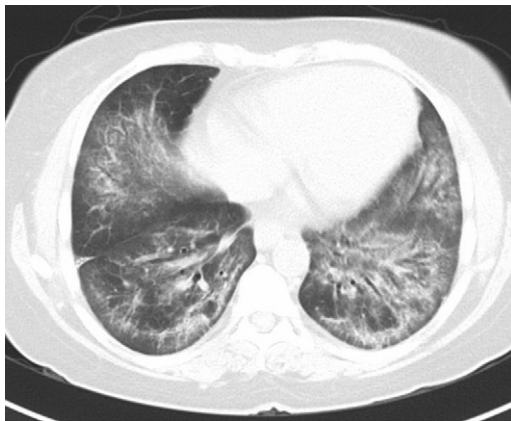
HRCT image of a patient with the antisynthetase syndrome. Note the bibasilar distribution of ground-glass opacifications suggestive of nonspecific interstitial pneumonia and the consolidative features suggesting organizing pneumonia.
